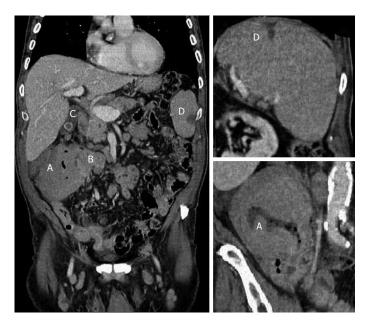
Coronal computed tomography scan (portal venous phase). The images show the large colic lesion at the level of the hepatic flexure (A), the large necrotic lymphadenopathy close to the lesion (B), the stone in the lumen of the gallbladder (C) and the hypodense area in the context of the spleen indicative of the ischemic outcomes (D).
